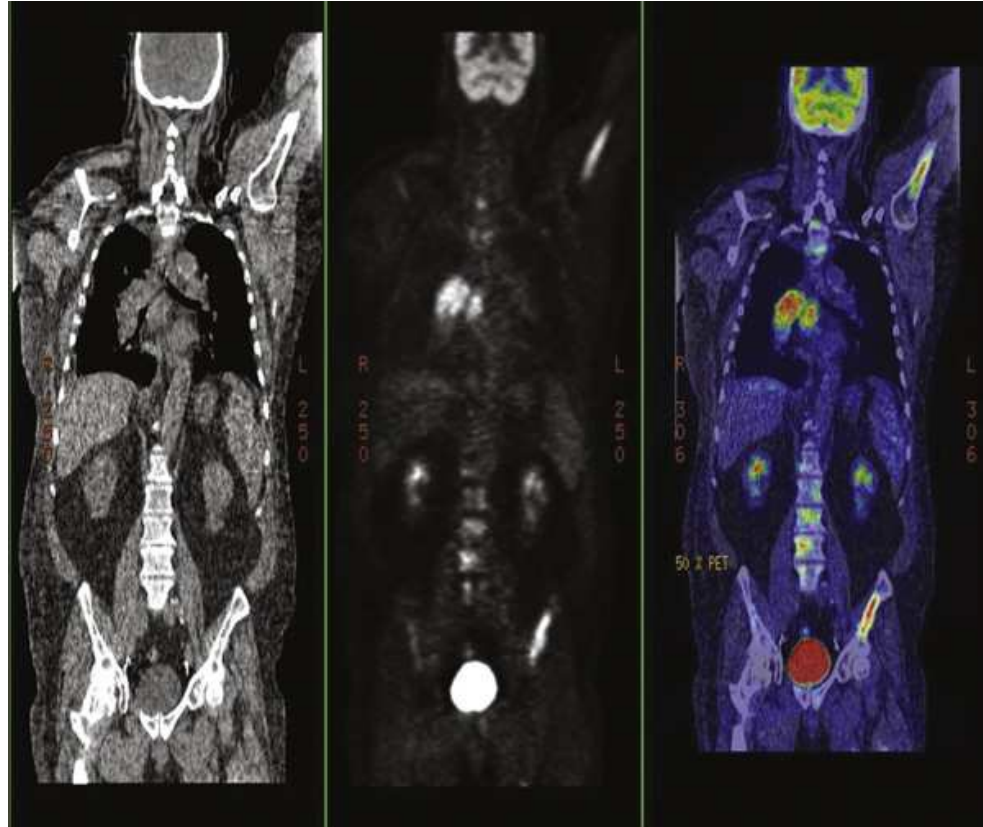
PET FDG image with CT fusion shows large hypermetabolic right lung mass. Many PET FDG studies are done for lung cancer because of its high glucose metabolism.
